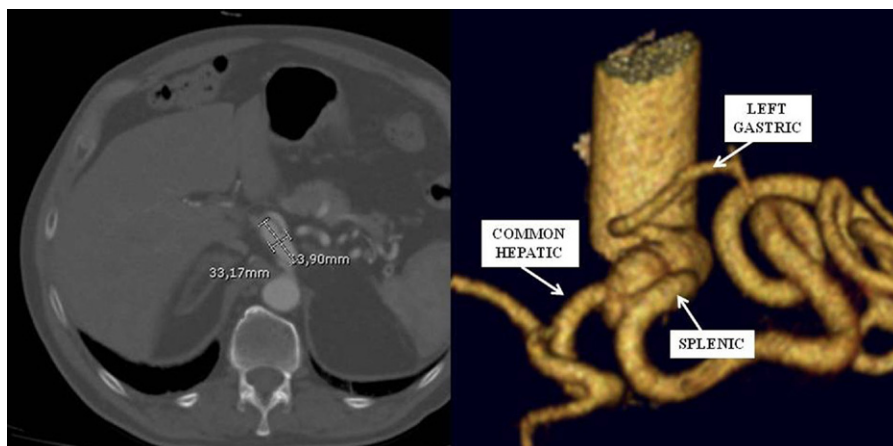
Computed tomography angiography of the celiac aneurysm with 3-dimensional reconstruction shows (Left) the fusiform shape of the sac with its relative sizing and (Right) the origin of the parent vessels directly from the aneurysm.
